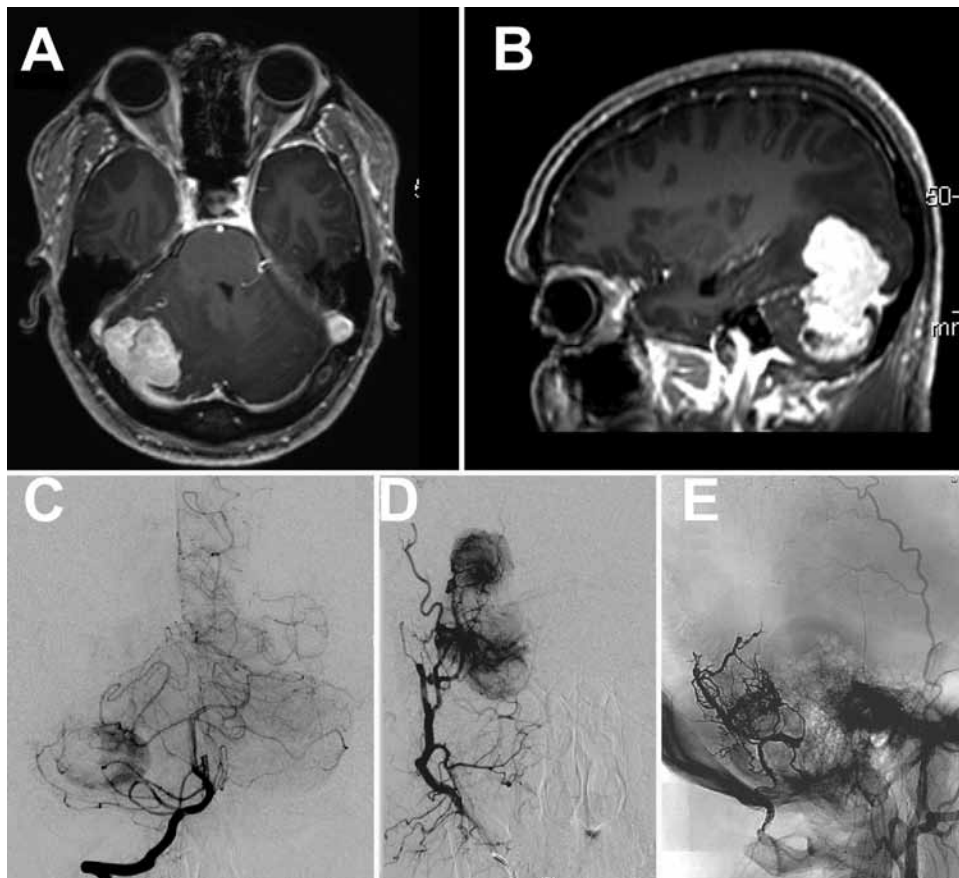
Case 3. Preoperative axial (A) and sagittal (B) post-Gd T1-weighted MR images demonstrating a homogeneously enhancing lesion near the right transverse sinus, extending into the supratentorial space and the posterior fossa. Selective right vertebral artery injection angiogram (C), posterior-anterior projection, demonstrating tumor blush with feeders from the superior cerebellar artery and anterior inferior cerebellar artery enhancing the posterior fossa component of the tumor. External carotid artery injection angiogram (D), posterior-anterior projection, showing feeders and tumor blush from the occipital artery. External carotid artery angiogram (E), lateral projection, demonstrating the liquid embolic material used to embolize feeders arising from the occipital artery.
